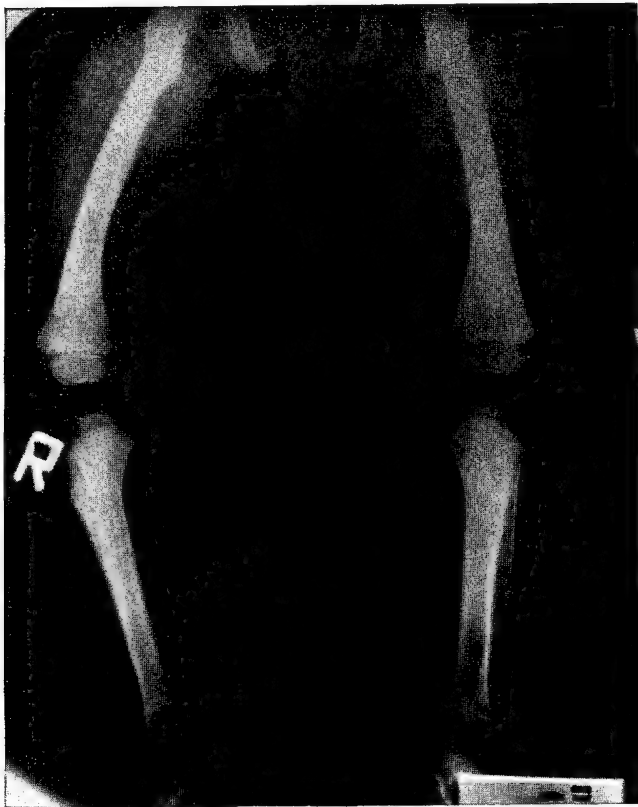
Roentgenogram of lower extremities.
